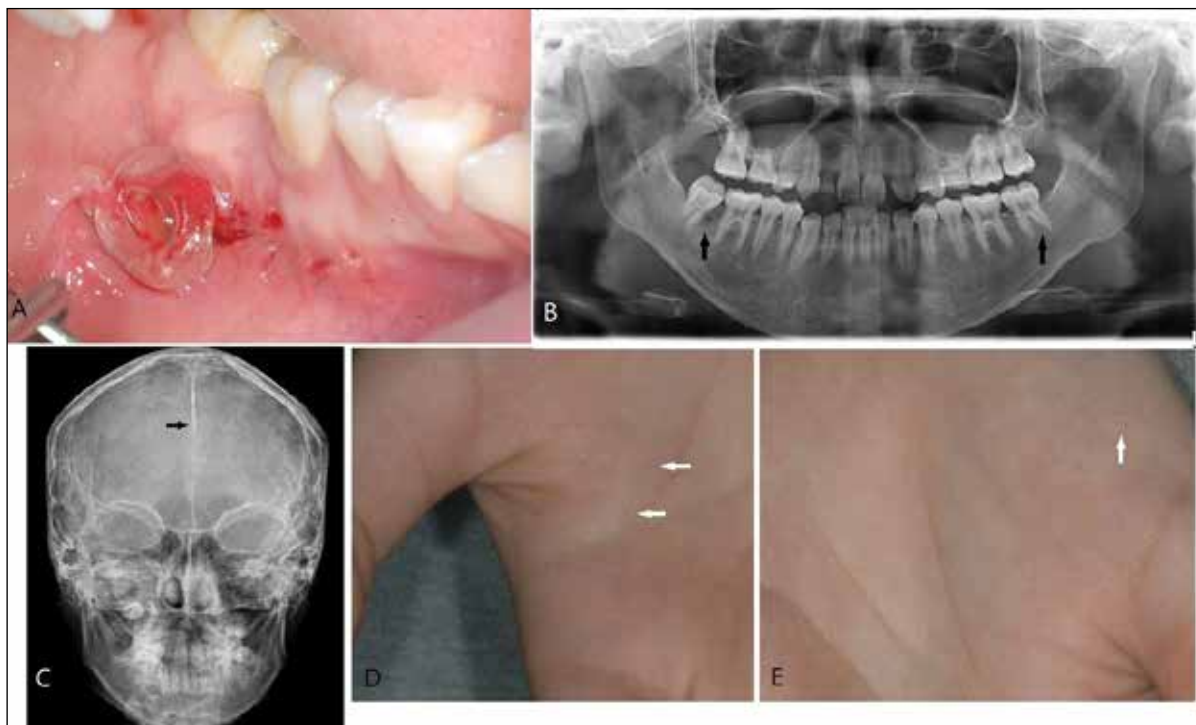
(A) Figure of maintenance tube inserted in the right second molar area after final decompression and peripheral osteotomy. (B) 7-year follow up panoramic view showed reduced radiolucency in mandibular right second molar and complete recovery in mandibular left second molar (C) Posteroanterior skull radiograph reveals calcification of the falx cerebri. (D) Two palmar pits on the right palm. (E) One palmar pit on the left palm.
